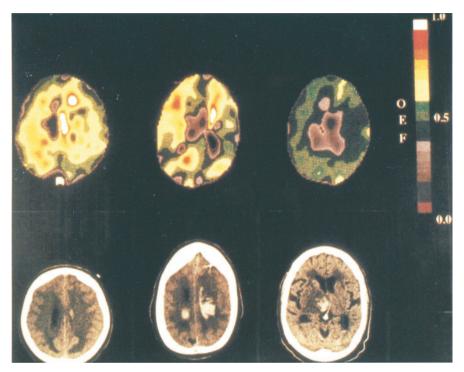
Hemorrhage size and oxygen extraction fraction. A range of changes on oxygen extraction fraction can be observed in intracerebral hemorrhage. In the patient at left, the CT scan (bottom left) shows a fairly small hemorrhage, but the PET image (top left) shows two significant regions of increased oxygen extraction. The patient at center has a larger hemorrhage as demonstrated on CT scan (bottom center), but PET image shows little increased oxygen extraction fraction (top center). The patient at right has a moderate-sized hematoma (bottom right) but with no elevation in oxygen extraction (top right)
